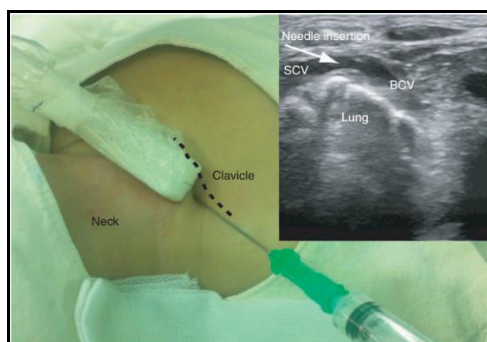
Ultrasound imaging shows the right SCV along its longitudinal axis, including a demonstration of the SC approach's probe application. In the ultrasound picture, the SCV puncture site and the needle's movement are indicated by an arrow. Obtaining a US image for the SC approach requires placing a US probe in the SC region, and the needle needs to be adjusted for the in-plane approach. The brachiocephalic vein (BCV) and the subclavian vein (SCV).
